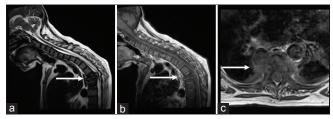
(a-c) Magnetic resonance imaging images showing altered signals of D6 and D7 vertebrae
